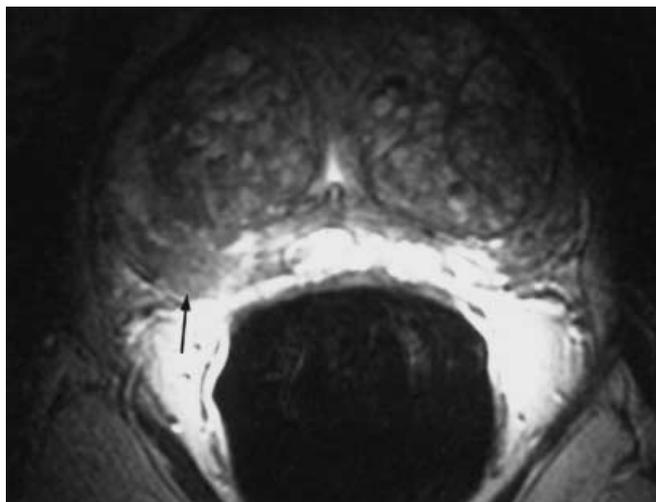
Prostatic carcinoma. Axial T2-weighted image in a 62-year-old patient shows diffuse low signal intensity in both peripheral zones of the prostate. Although there is flare artifact which degrades the image, there is an asymmetrical low signal intensity in the right peripheral zone bulging the capsule (*arrow*) compatible with neoplasia. Biopsy results demonstrated bilateral prostatitis with adenocarcinoma in the right lobe
